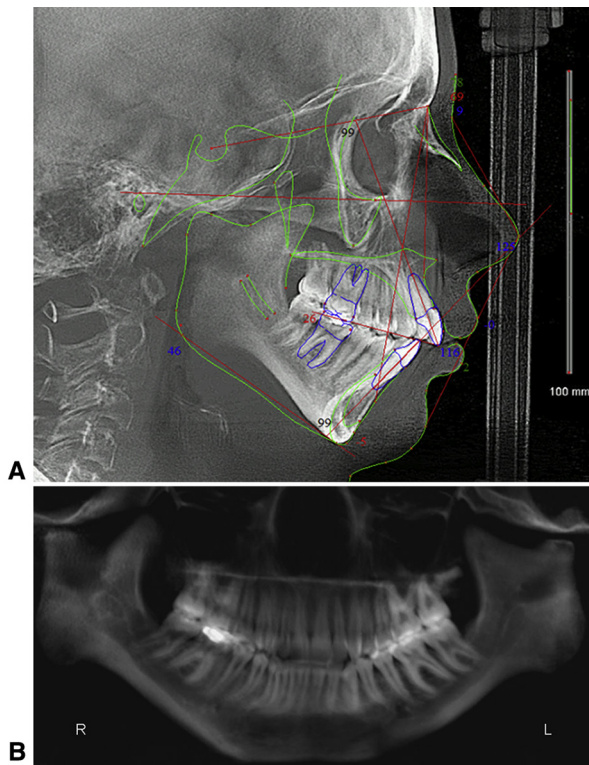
A, Pretreatment lateral cephalometric radiograph with tracing. B, Pretreatment panoramic radiograph.
